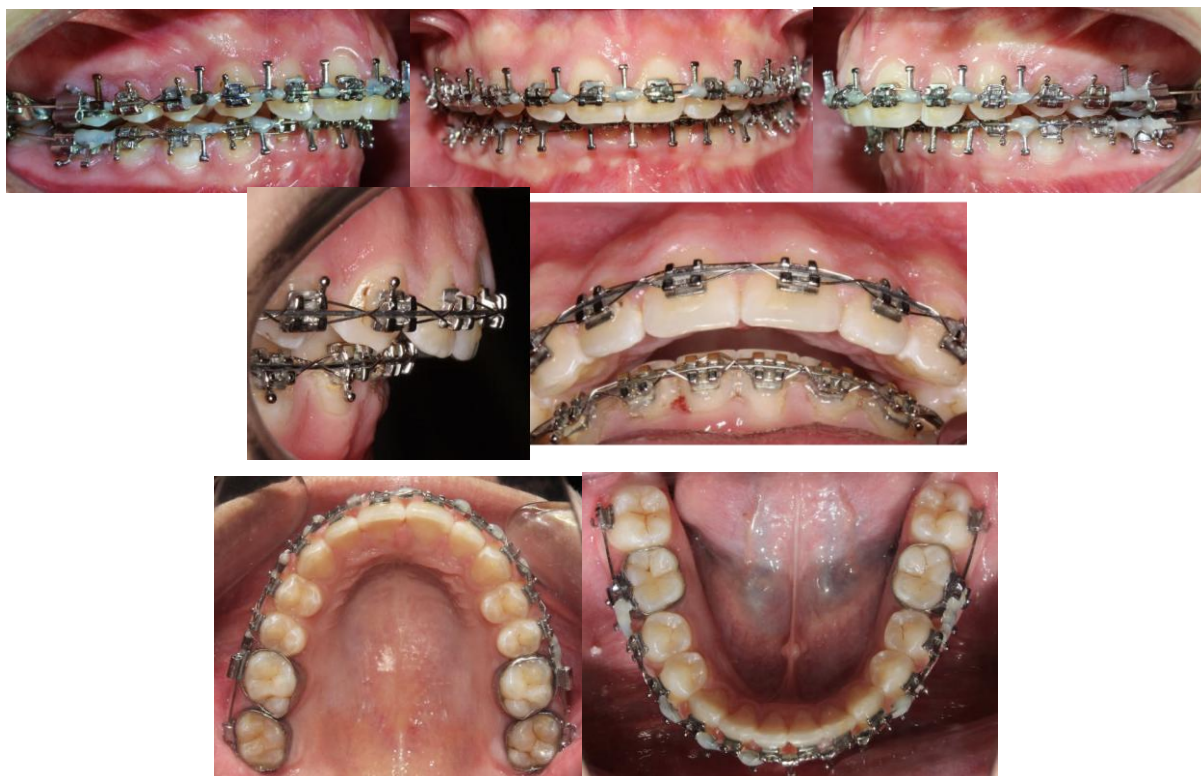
Lateral Skull and Panoramic Radiography, Pre-Surgical Intraoral and Extraoral Photographs and Occlusal Splint
